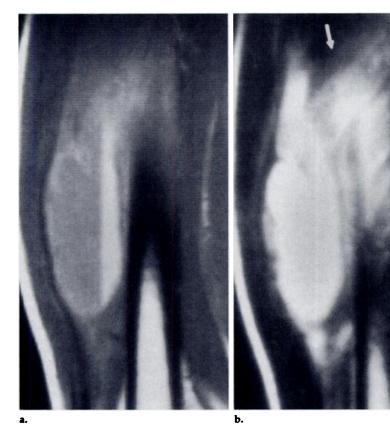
Sagittal MR images of the thigh in a 20-year-old man with 8-cm early myositis ossificans anterior to the middle of the femur, deviating the quadriceps anteriorly. (a) On this SE 1,000/30 image, fluid that is slightly hyperintense to muscle forms a layer above markedly hyperintense fluid. Margins are irregular. The hypointense line seen posteriorly represents calcification but cannot be distinguished from a pseudocapsule such as that seen in Figure 1. (b) On this SE 2,500/65 image, peritumoral high signal intensity (arrows) surrounds an inhomogeneous mass that is predominantly hyperintense to fat.
